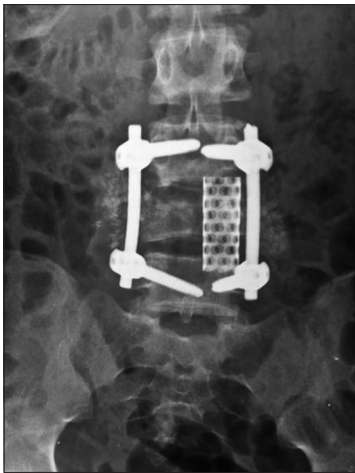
Postoperative anteroposterior X-ray showing posterior fusion by rod and screws, anterior fusion by titanium mesh cage
